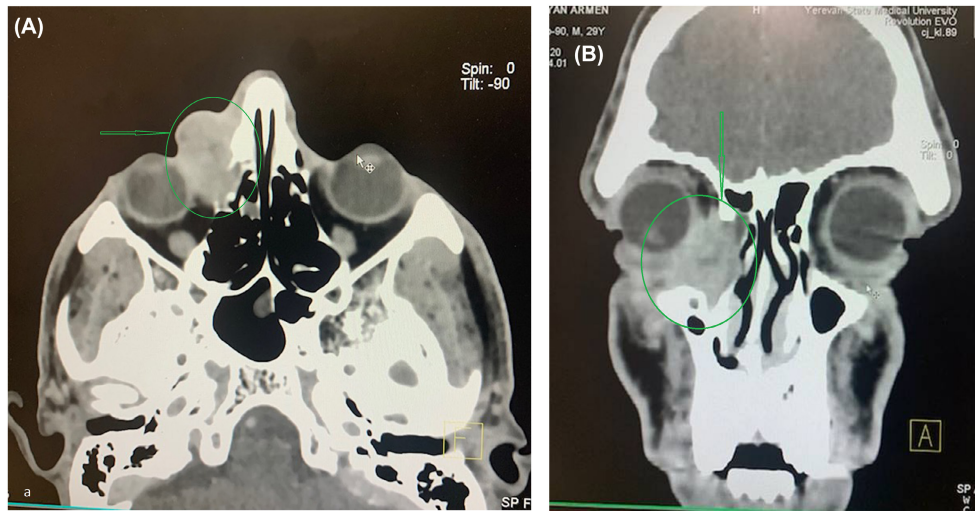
Post-contrast-enhanced CT shows tumor extension from the lacrimal sac/duct into the medial canthus, medial rectus muscle, ethmoid, nasal cavity, medial concha, and maxillary sinus: axial view (A), coronal view (B).
